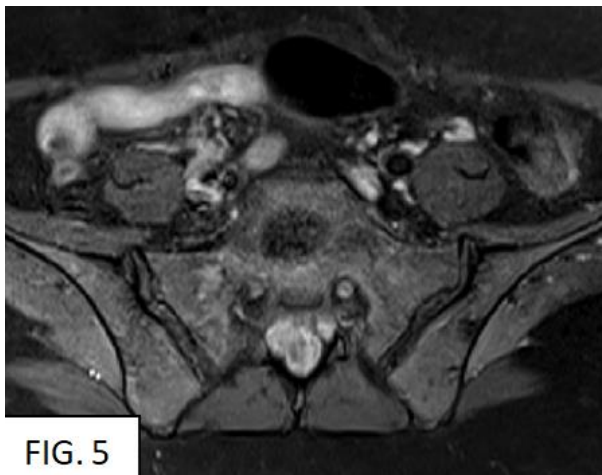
MRI Axial STIR - S1 vertebral body level.
